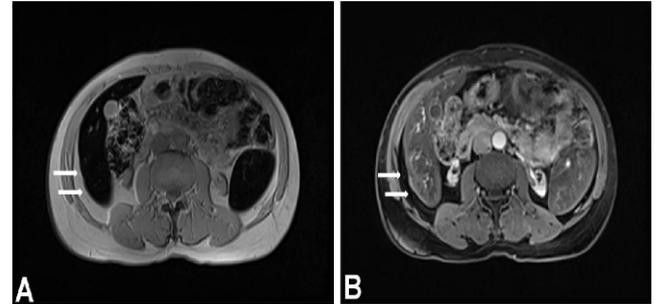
At second control MRI after one year follow-up T1WI (A) and T1 with contrast image (B) show complete disappearance of the lesion (arrow).
